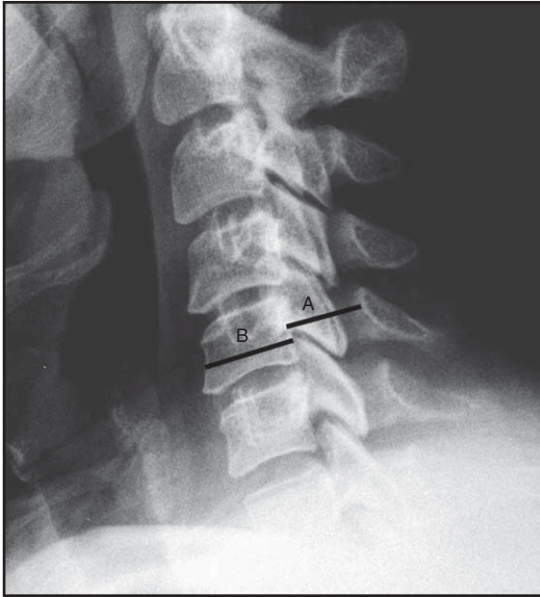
A lateral cervical spine radiograph depicting the measurements for cervical spinal stenosis. Line 'A' indicates the anteroposterior dimension of the cervical spinal canal, measured from the posterior vertebral body to the spinolaminar line. Line 'B' indicates the anteroposterior width of the vertebral body. The Torg ratio is defined as A/B. Cervical spinal stenosis has been defined by a cervical spinal canal diameter of ≤ 13 mm or a Torg ratio of < 0.8 .
